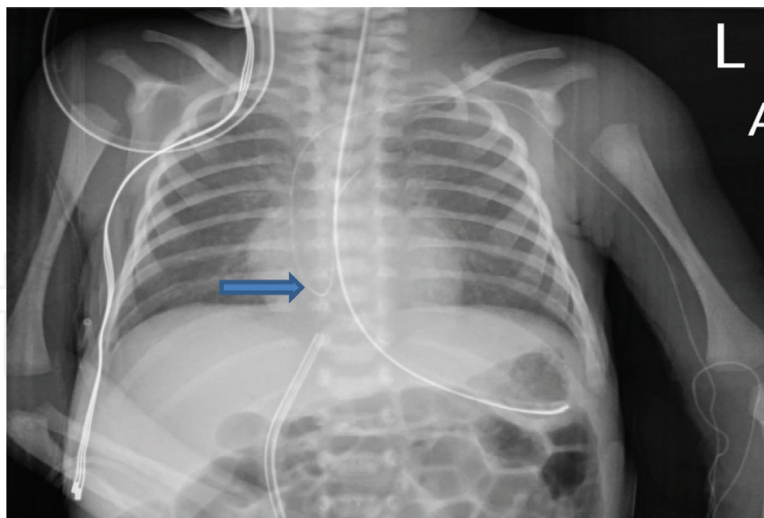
PICC line with intracardiac looping. Chest X-ray shows left PICC line passed superior vena cava, got looped in right atrium.
